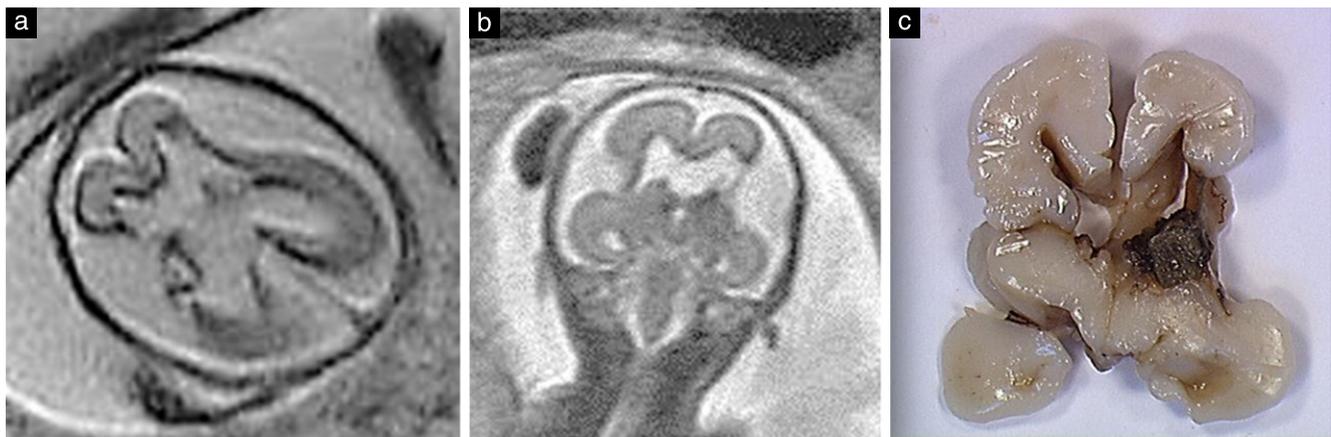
Fetal imaging in a patient referred at 22 gestational weeks due to enlarged pericerebral space with mild decrease in cephalic biometry (5th percentile). Axial (a) and coronal (b) T2-weighted fetal magnetic resonance images demonstrating major amputation of cerebral parenchyma adjacent to the insula, more pronounced on the left hemisphere, associated with no evidence of the septum pellucidum. Major increase of the pericerebral space adjacent to the clastic changes was also noted. (c) Macroscopic pathological examination confirmed clastic lesions adjacent to the insula with both porencephalic lesions and bilateral pseudoschizencephalies related to an ischemohemorrhagic phenomenon.
